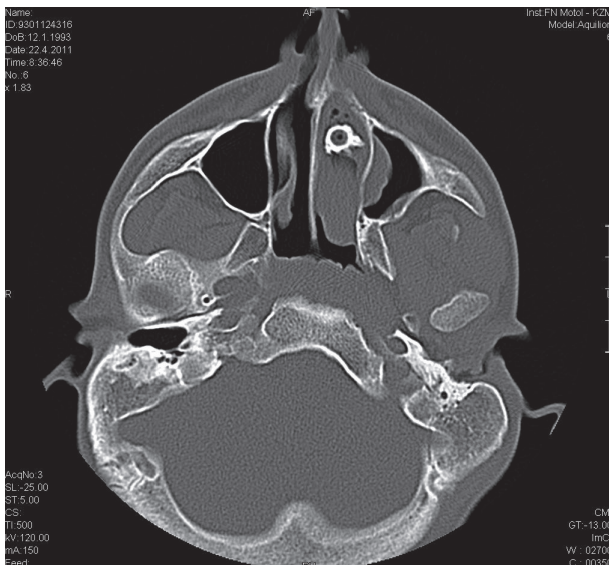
CT sequence of the skull with the foreign body in the nasal area.
